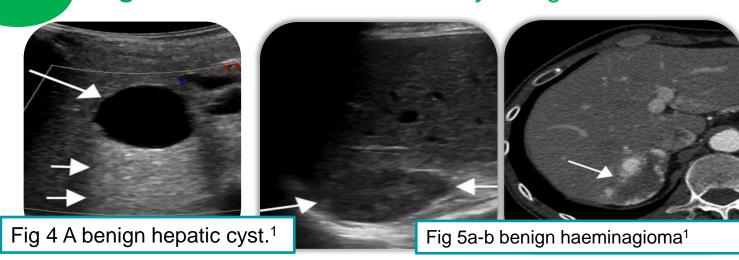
b 49-yearold male with chronic hep B. Initially suspected as HCC but review of prior CT confirmed benign hemangioma. (US-1)¹
